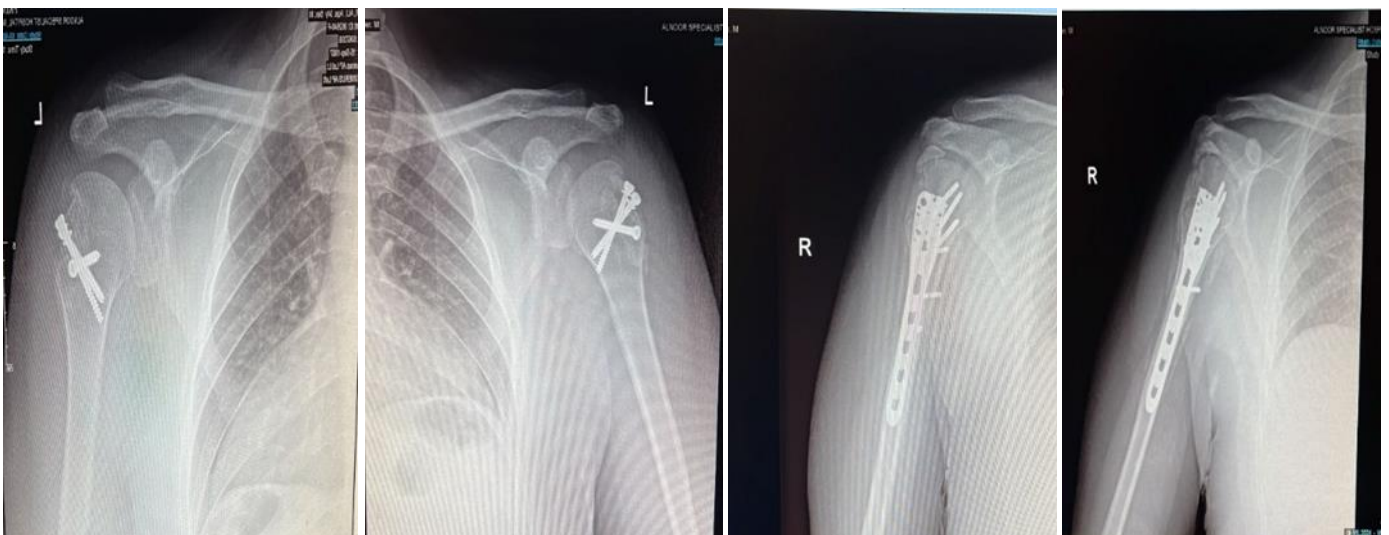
X-rays of right and left shoulders after open reeducation and internal fixation for the bilateral shoulder
